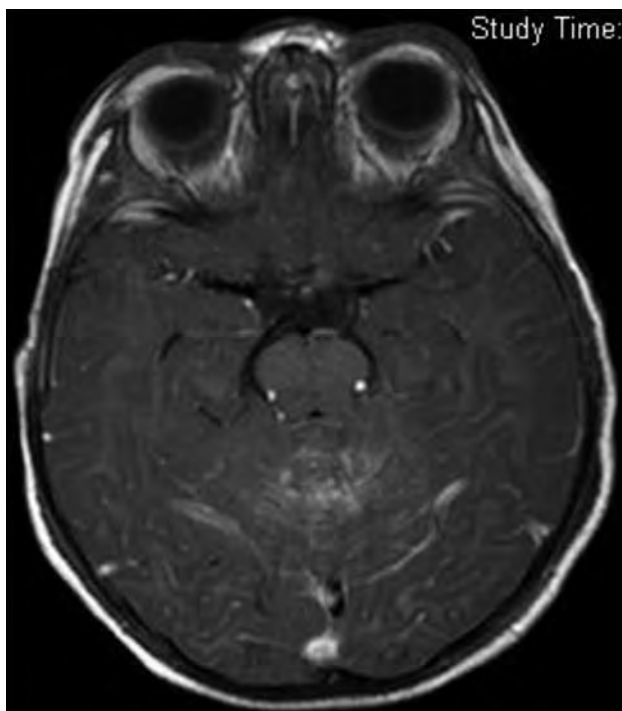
Patient 3. Magnetic resonance imaging scan showing leptomenigeal enhancement at the superior aspect of the cerebellar vermis.
